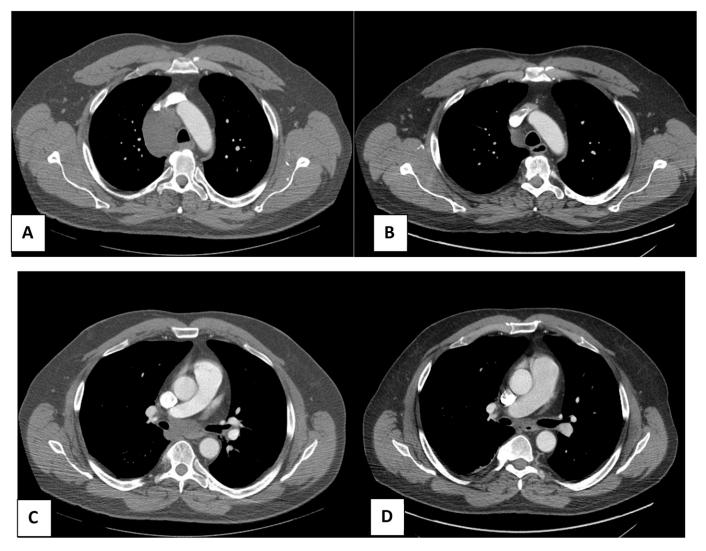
(*A* and *B*) Chest computer tomography (CT) showing bronchogenic cyst in the right paratracheal area, (*A*) before aspiration and (*B*) after aspiration. (*C* and *D*) CT sections in the subcarinal area (*C*) before aspiration and (*D*) after aspiration.
